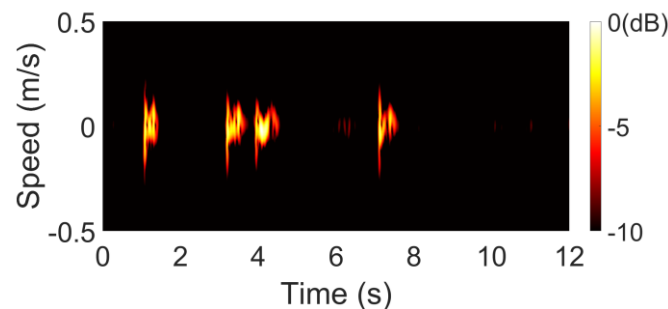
Micro-Doppler signature due to the eyes-blinking during diaphragmatic breathing.
